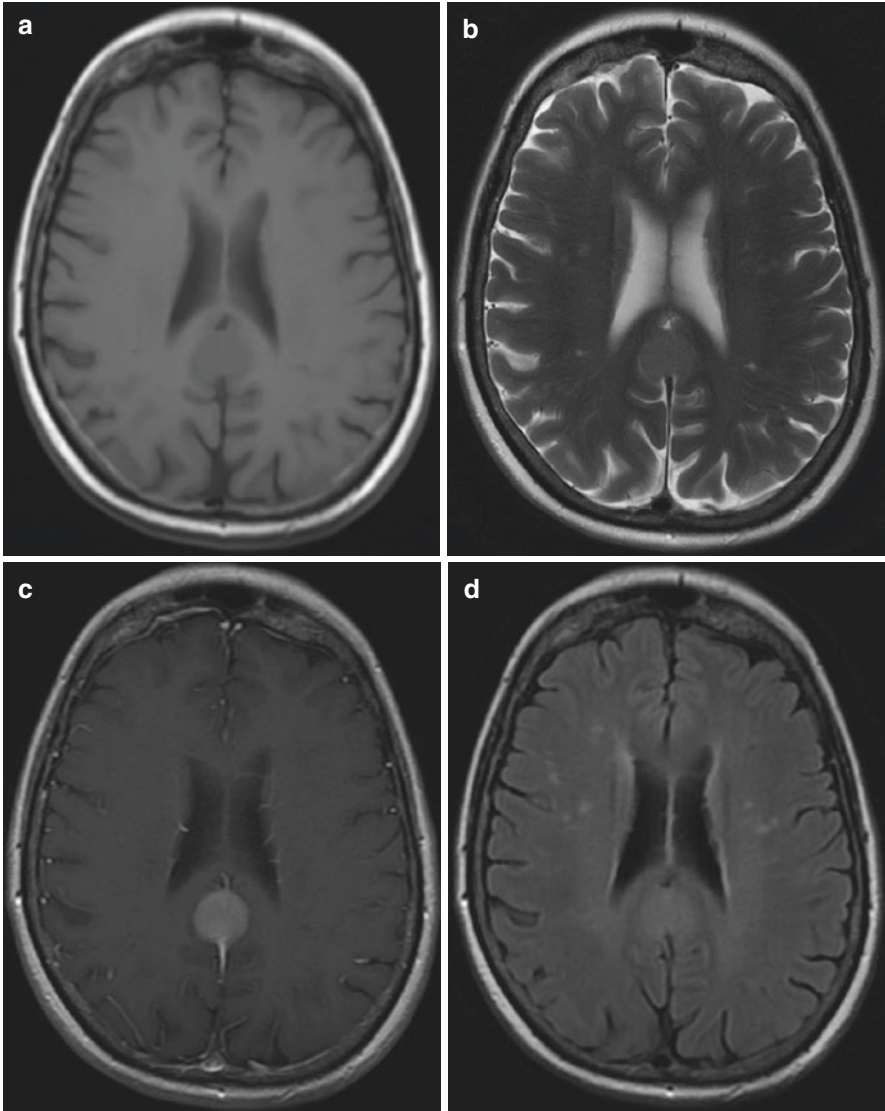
Falcotentorial meningioma in TIWI (a), T2WI (b), T1WI with contrast (c), and FLAIR (d) MRI sequences
